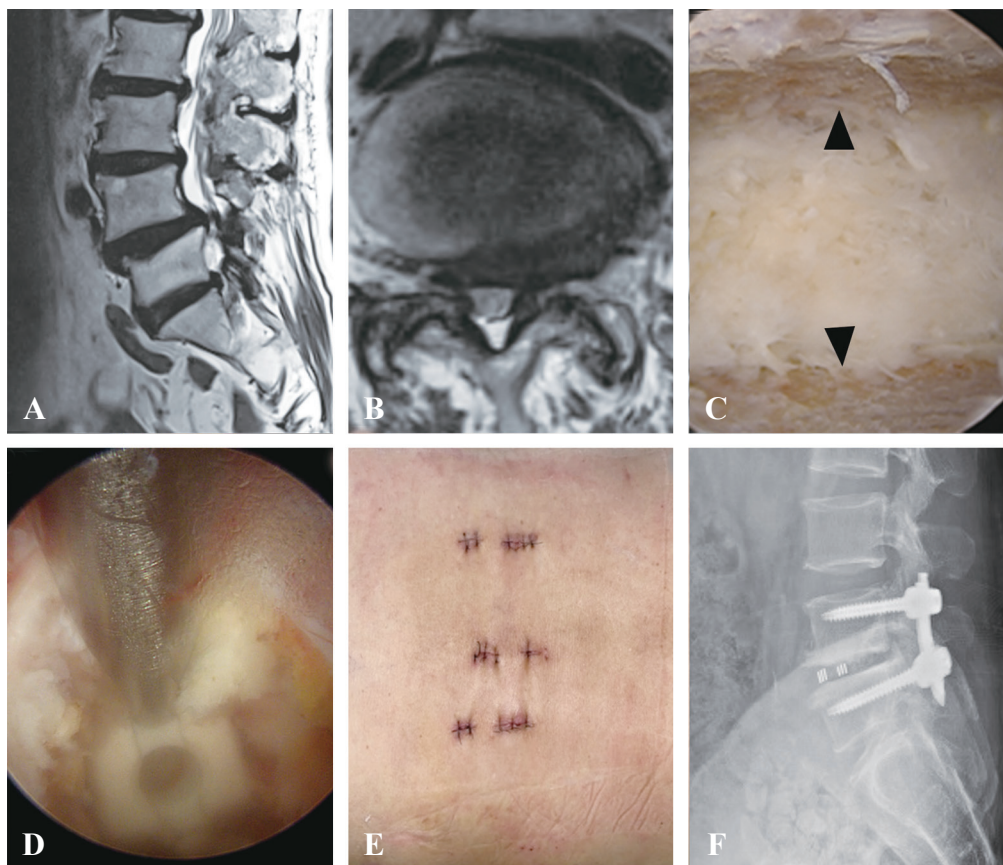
(A, B) Patient with severe central stenosis and grade 1 spondylolisthesis at L4-5 undergoing biportal endoscopic transforaminal interbody fusion. (C) Biportal endoscopic approach providing clear visualization of endplate preparation, enabling complete preparation (black arrowhead). (D) Safe cage insertion achieved under endoscopic guidance. (E) Six small incisions visible: two for endoscope access and four for percutaneous screw insertion. (F) Postoperative lateral lumbar radiograph showing anteriorly positioned lumbar cage and four inserted pedicle screws.
